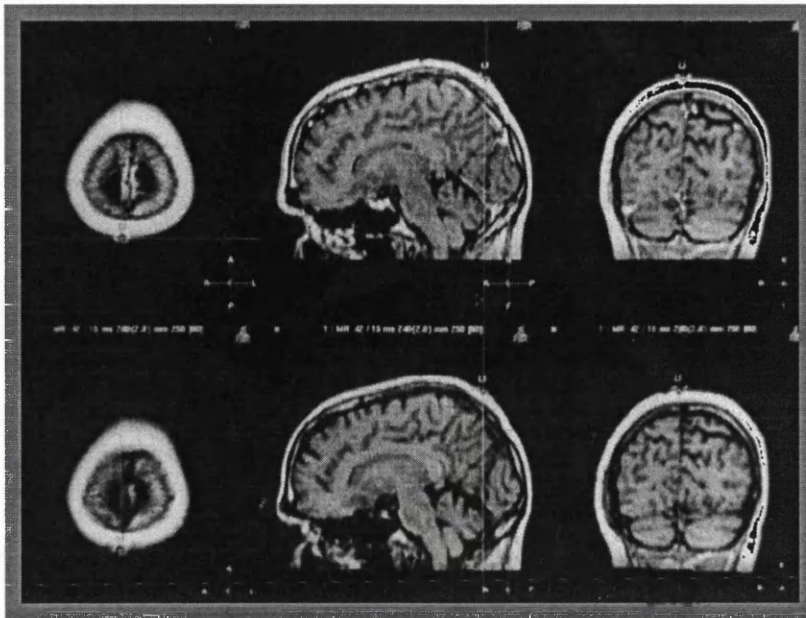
The landmark method of image data set fusion. Identical imaging protocols simplified the selection of landmarks in the pre- and post-operative image data sets on the CT/MR workstation.
